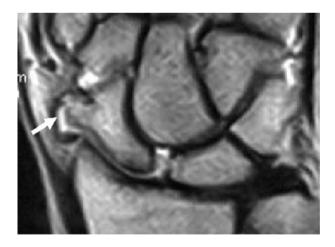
Arthro-MRI, SE T1 SLAC 1: osteophytosis of the distal pole of the scaphoid (arrow). This condition is typical of dynamic scapholunate dissociation. It may be observed that the scapholunate ligament is intact and that the contrast medium spreads into the intercarpal joint compartment (the cm has been injected into the radiocarpal joint compartment): this condition is consistent with a partial injury of the interosseous ligament
